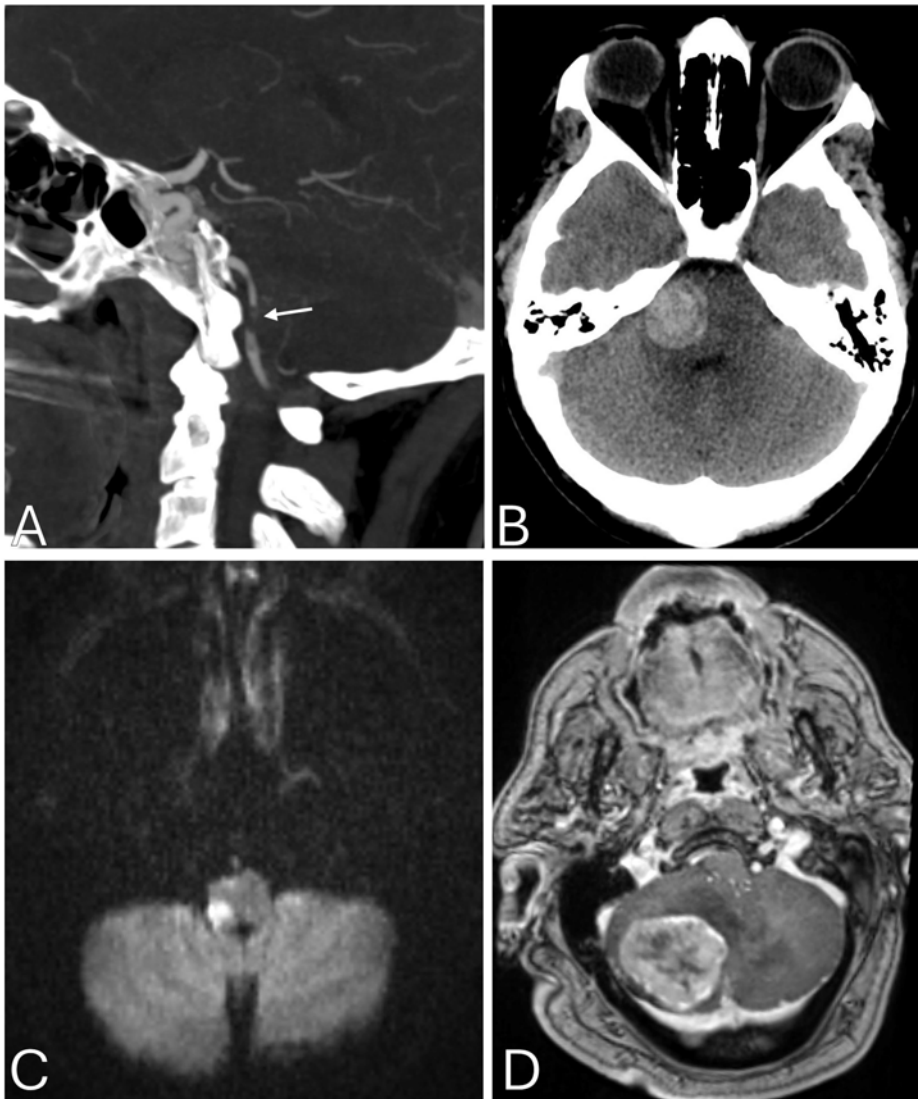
Neuroimaging finding examples in patients who presented with dizziness. A) Sagittal CTA showing occlusive thrombus in the right V4 vertebral artery. B) Axial non-contrast CT showing right pontine hemorrhagic mass. C) Axial DWI showing a right medulla infarct (Wallenberg Syndrome). D) Axial post-contrast T1 image showing metastatic esophageal adenocarcinoma in the right cerebellum.
